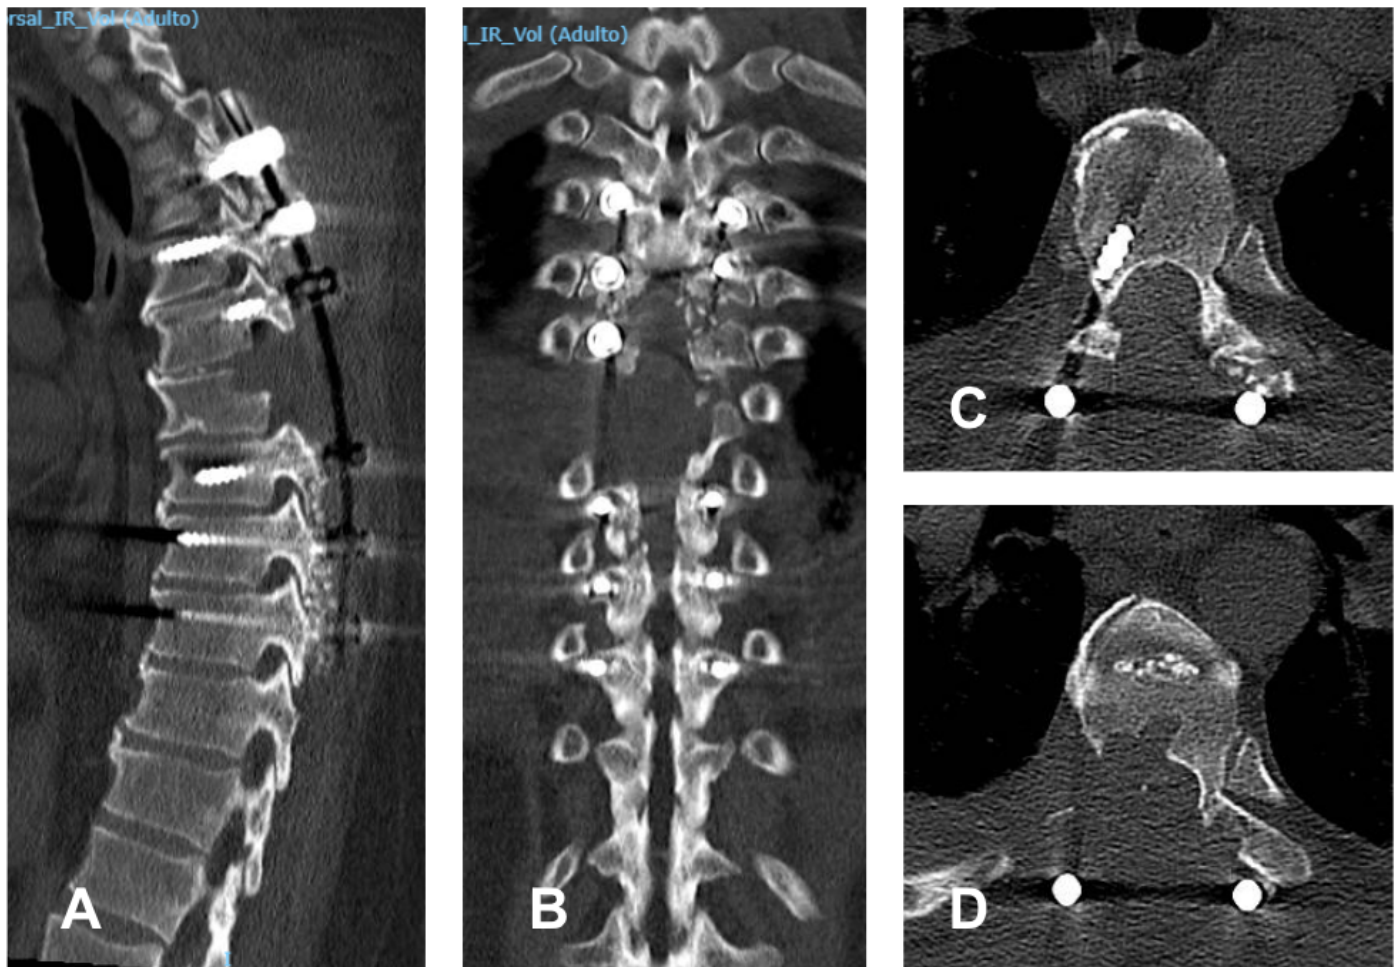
CT of the dorsal spine, sagittal (A), coronal (B), and axial (C and D) section 10 days after surgery. Spinal cord decompression and pedicle screw positioning were observed.
